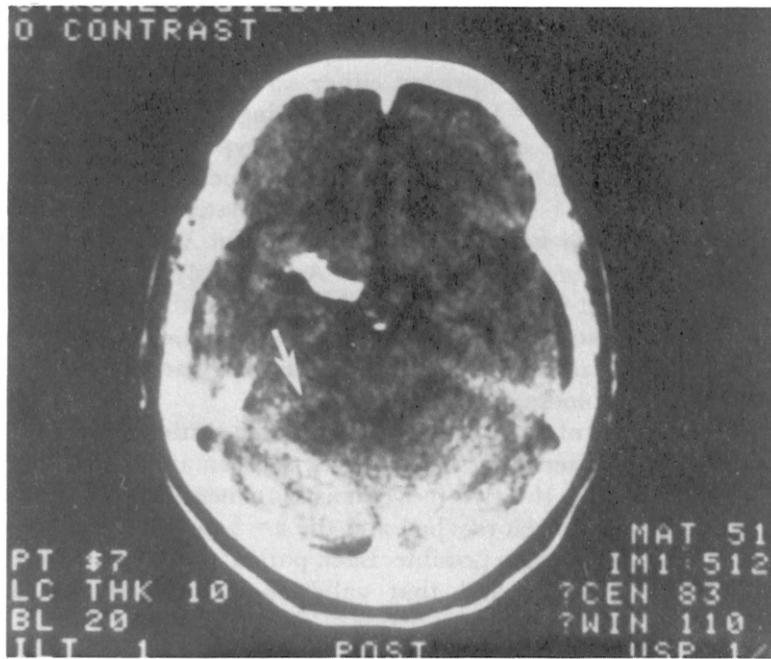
CT scan of patient ZS. Note the infarcted lateral cerebellar structure.
